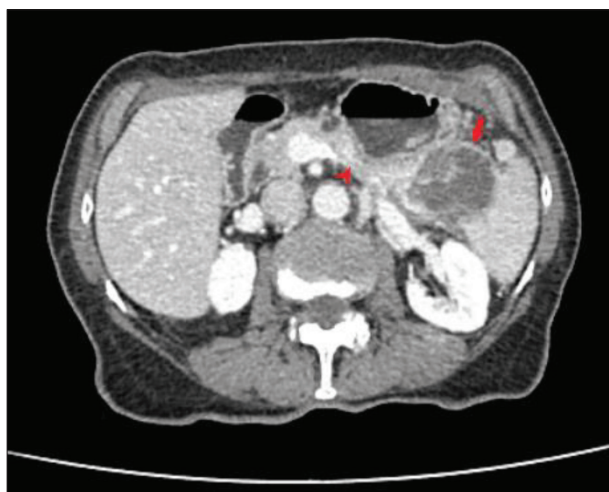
Axial contrast-enhanced computed tomography scan (125 ml iodine contrast, 1 mm slice thickness); the necrotic lesion with post-contrast enhanced borders (arrow) which is in the contact with the gastric body and spleen capsule; thrombosed splenic vein (arrowhead)
